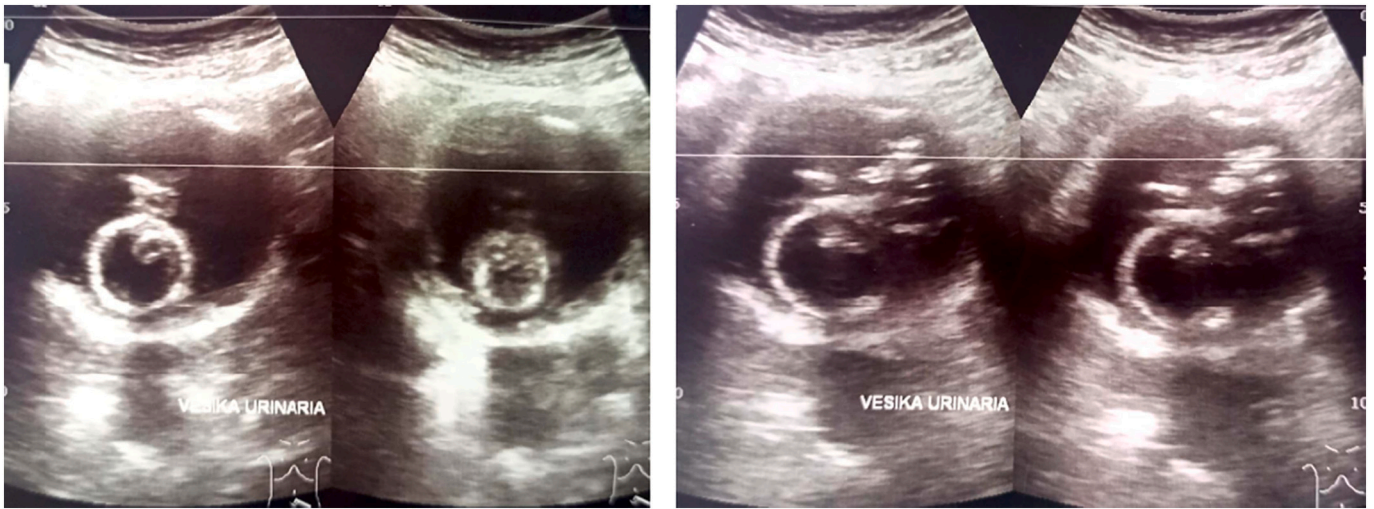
Ultrasonography of the bladder.
